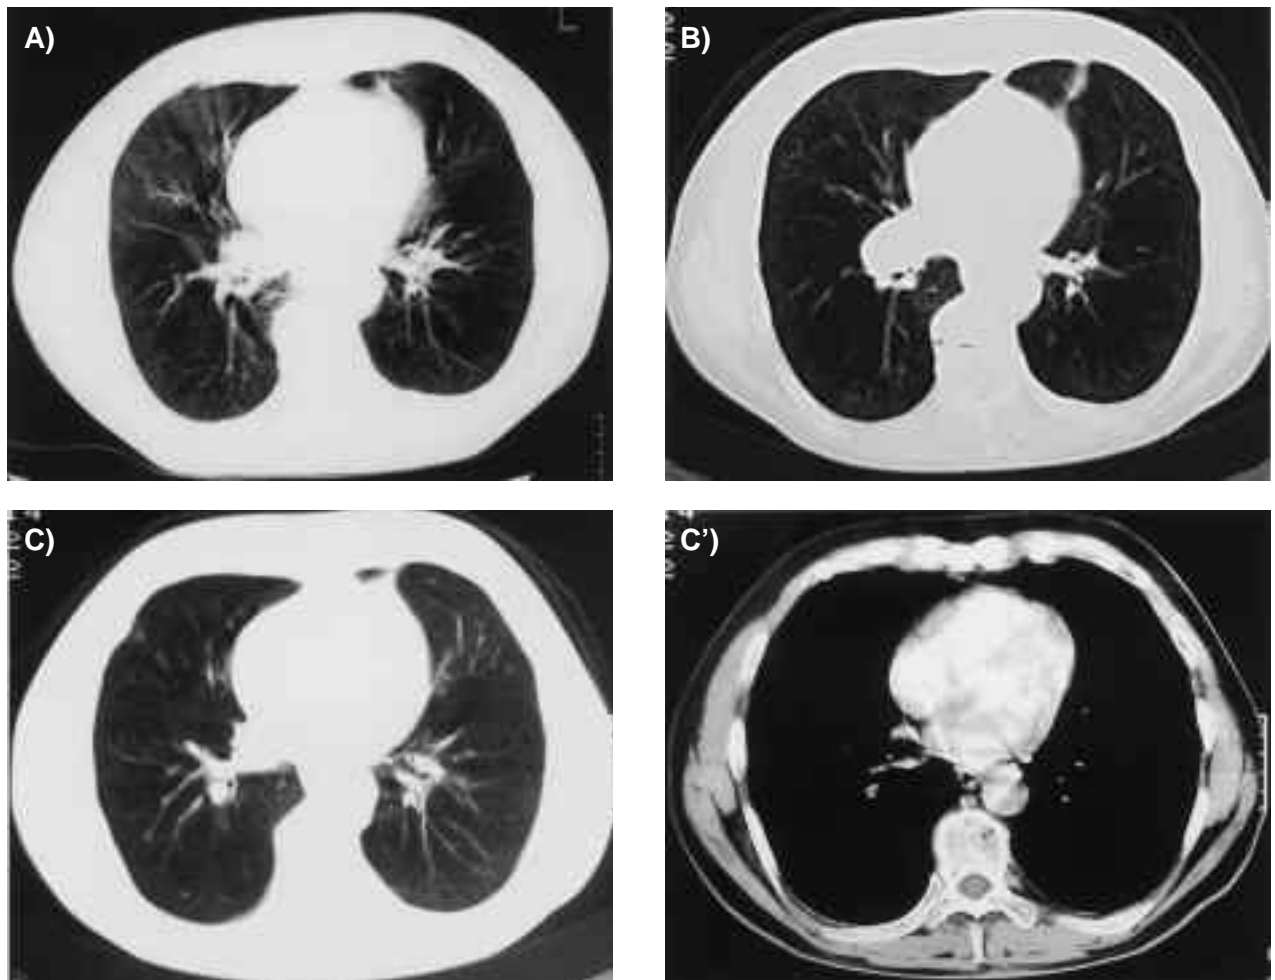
A. CT scan before treatment showing right hilar adenopathy (1.8 cm), as well as diffuse emphysema and pulmonary fibrosis. B. Progressive disease: CT scan performed 1 cm cranially to 'A' 30 months (eight cycles) after the beginning of immunotherapy showing the increased size of the hilar lesion (4 cm). Parenchymal consolidation with pleural attachment can also be seen in the lingula. C, C'. "Late" complete remission 60 months (16 cycles) after the beginning of immunotherapy: CT scans with lung (c) and mediastinum (c') windows showing the resolution of the hilar lesion and a residual fibrous scar.
